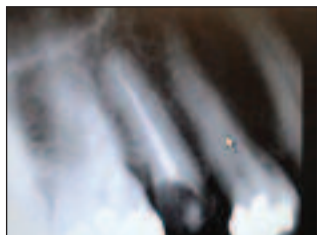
Periapical radiograph at U/R5
